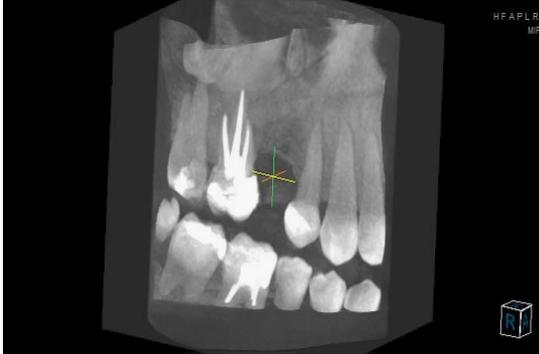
CBCT can be successfully used for the technical evaluation of root filling. It reveals the homogeneity and correct condensation technique, without gaps between dentin walls and endodontic material.
